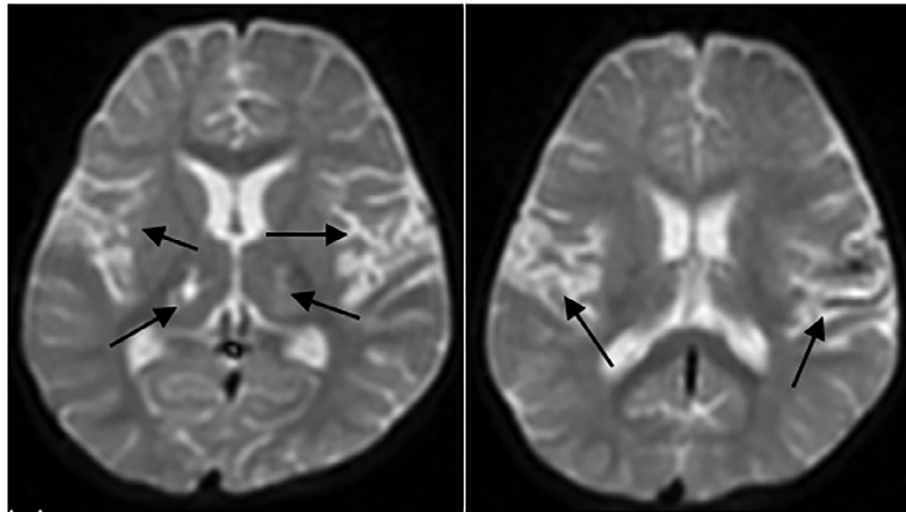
Magnetic resonance imaging (MRI) of a child with herpes encephalitis. MRI (T2-weighted axial image) reveals bilateral opercular, insular, and thalamic hyperintensities (shown with single arrows).
